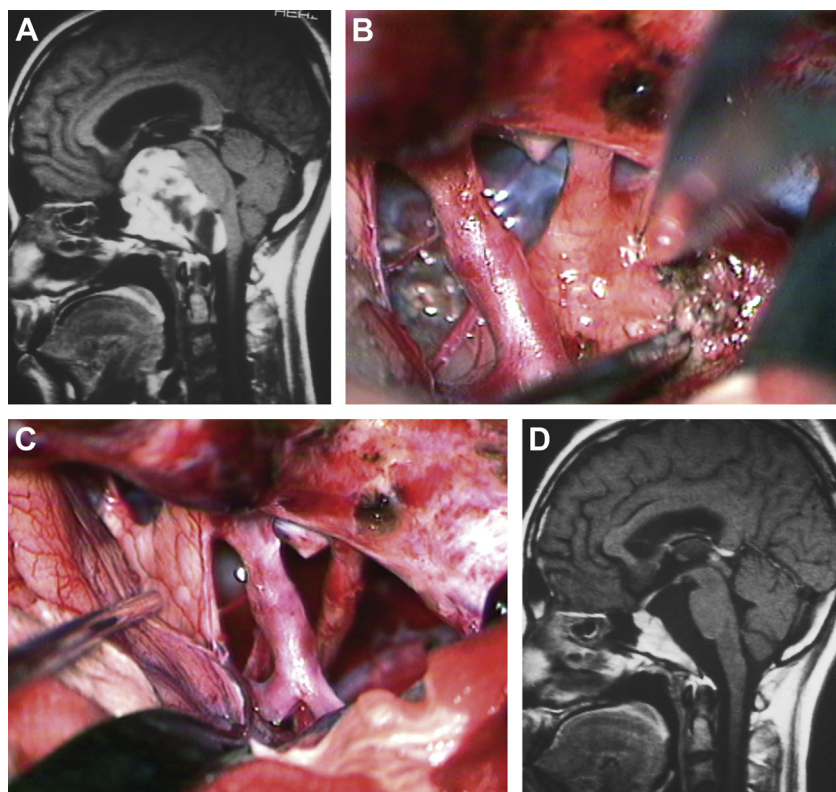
(A) Preoperative sagittal postcontrast T1-weighted magnetic resonance imaging (MRI) demonstrates an irregular lesion with heterogenous enhancement occupying the interpeduncular and the premedullary cisterns compressing the brainstem posteriorly. (B) A solid portion of the tumor that was located lateral to the right oculomotor nerve was exposed. The oculomotor nerve fused into the tumor at its cisternal segment. (C) Final view of the gross-total resection of the tumor. The oculomotor nerve was nicely preserved. (D) Postoperative sagittal postcontrast T1-weighted MR image demonstrates no residual tumor.
